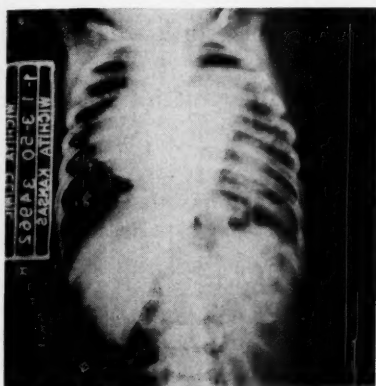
X-ray showing intestines and what was thought to be a portion of the liver in left chest.
